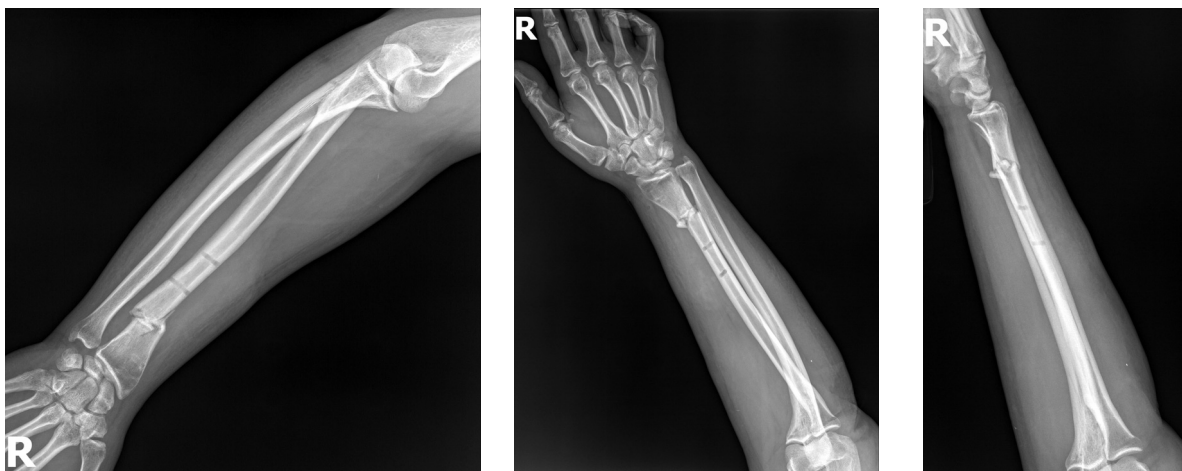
X-ray image of radius fracture after removal of external fixator (2 months after injury). Radiological signs of delayed union of the fracture
